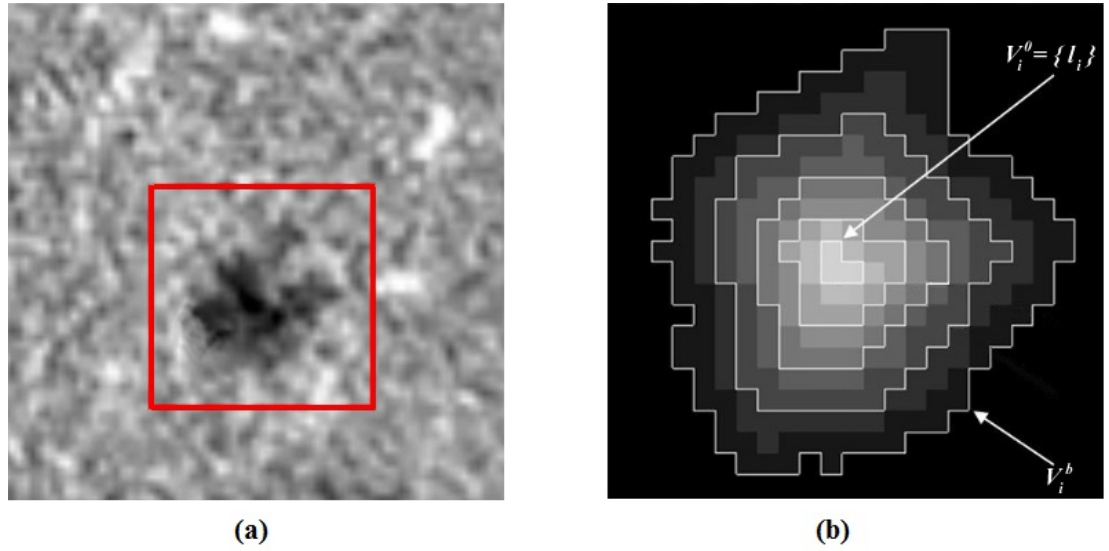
The abnormality level map for liver lesion; (a) Liver lesion CT image; (b) Liver lesion abnormality map involving in V embracing by l_i areas.
